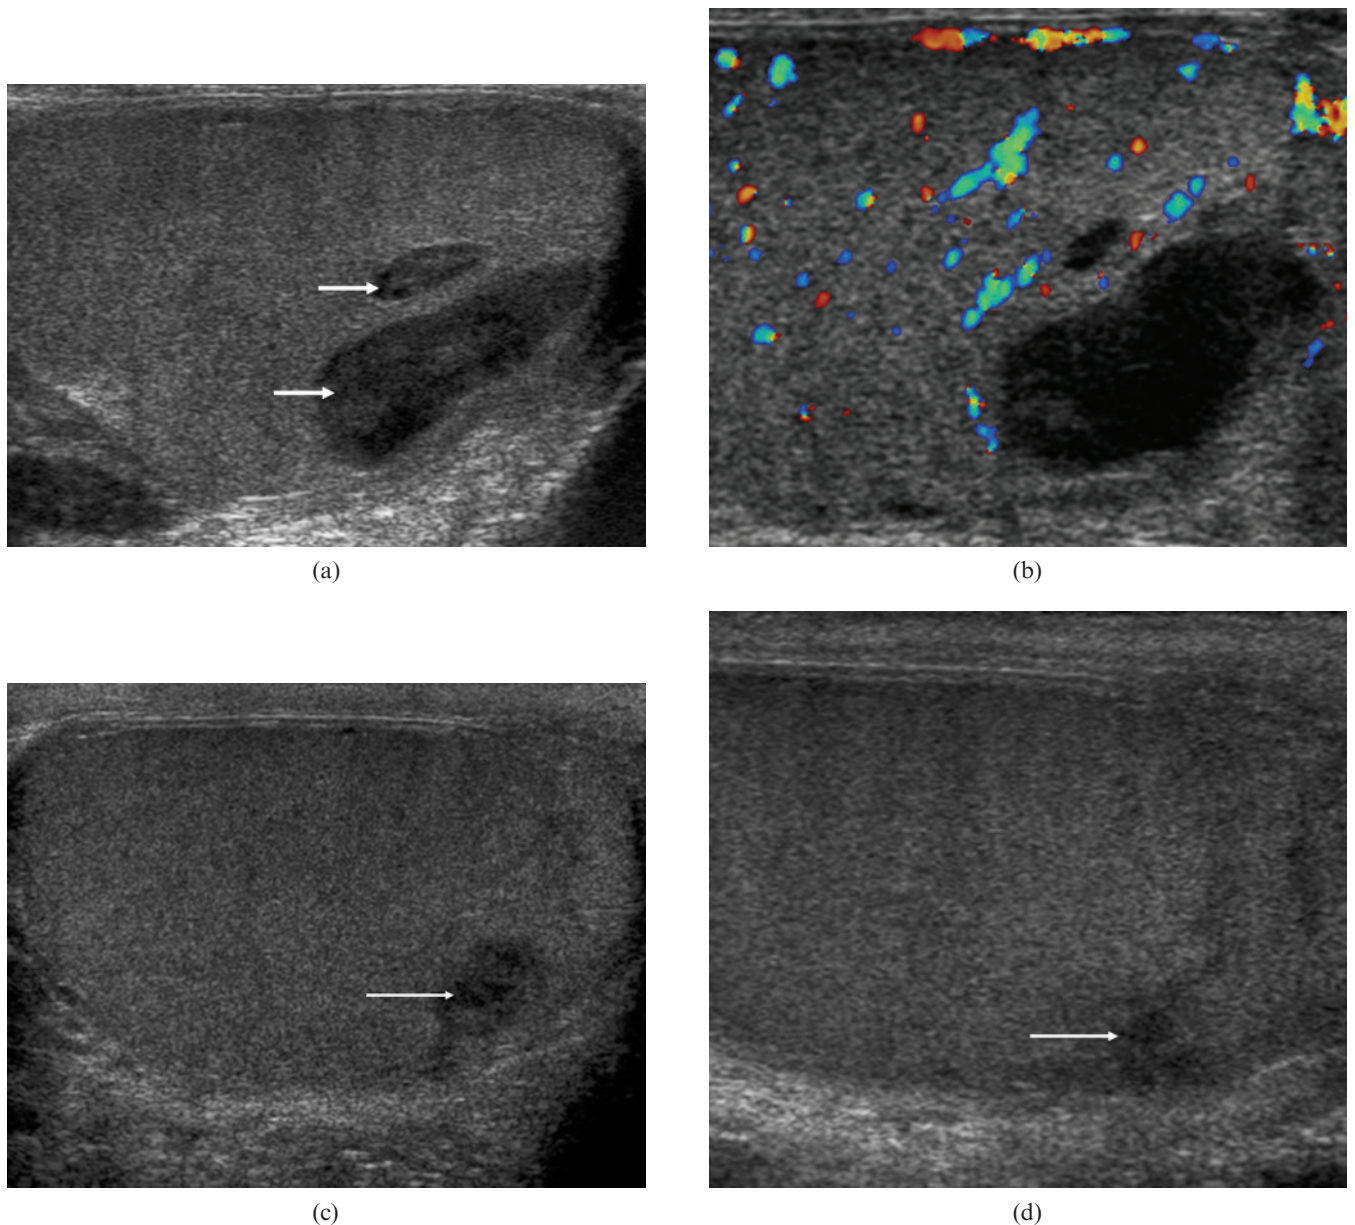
(a) Longitudinal image of the left testis demonstrating two low reflective intratesticular lesions (arrows) with evidence of internal areas of high reflectivity. (b) Colour Doppler image, on optimal low flow sensitivity, of the two lesions demonstrating no internal colour Doppler signal within the low reflective areas. (c) At the 1 month follow-up examination only a single low reflective lesion remains (arrow) with central echoes present. No internal colour Doppler signal was present in the lesion. (d) At 3 months the lesion has regressed further (arrow) appearing as an ill-defined area of low reflectivity with some internal echoes.
